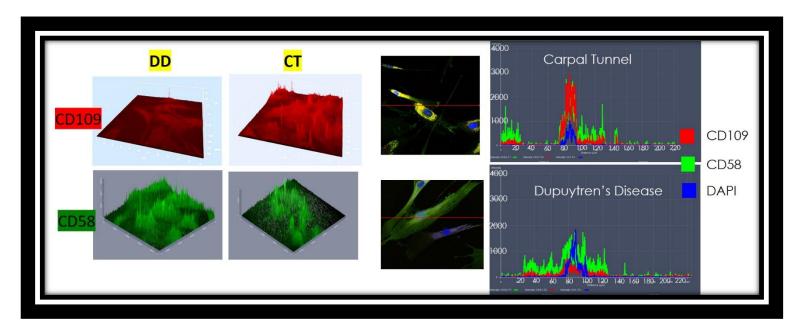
CD58 levels are similar in DD when compared to CT, while CD109 levels are significantly decreased in DD compared to CT. The figure is representative of 3 experiments using fibroblasts from 2 patients each
